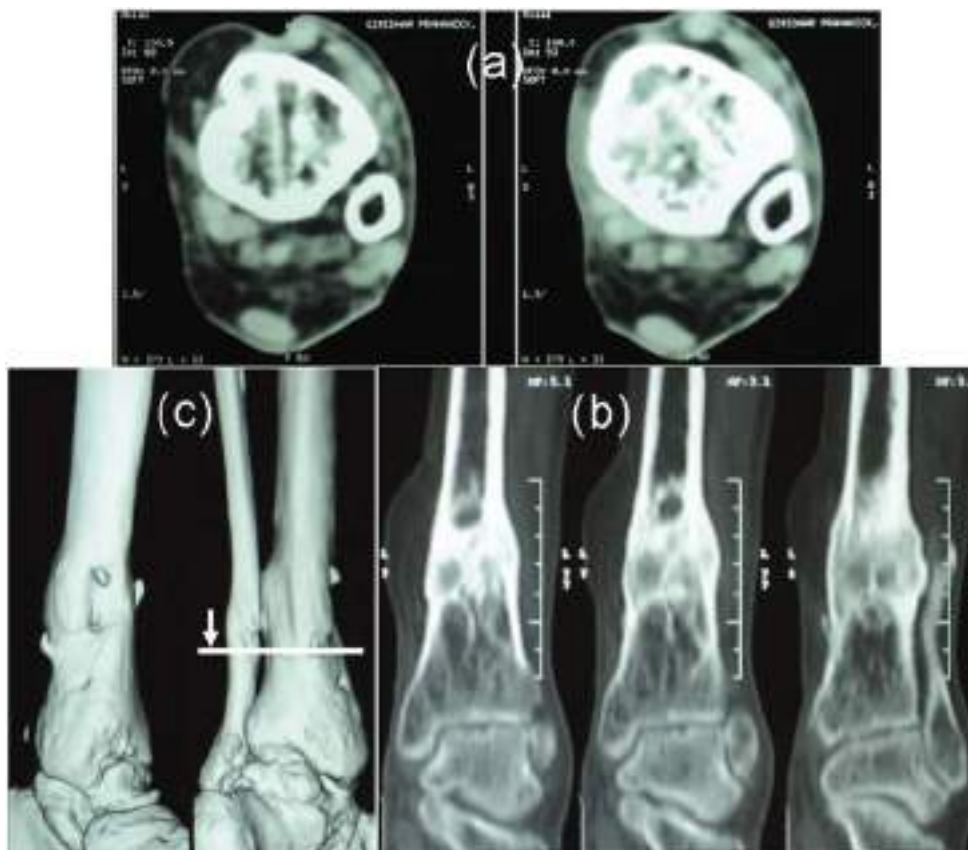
Post-operative CT pictures of healed osteomyelitis bone. 2-dimensional CT studies of operated area in different cross sections (a), longitudinal sections (b) and its 3-dimensional reconstruction (c) performed after 8 months (with permissions from Elsevier).
